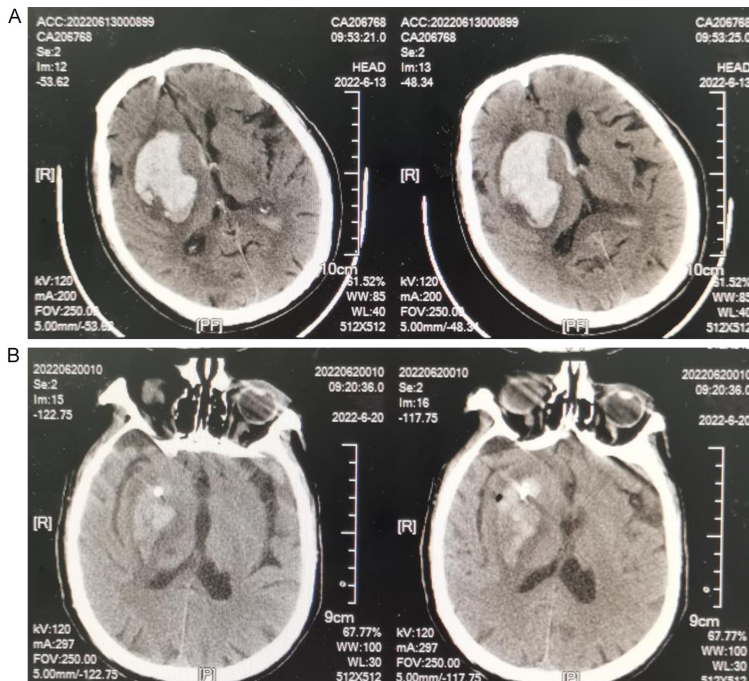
Preoperative and postoperative Computed Tomography (CT) scans of basal ganglia lateral region hemorrhages. Note: (A) Preoperative CT imaging. (B) Postoperative CT imaging at 48-hour follow-up.
